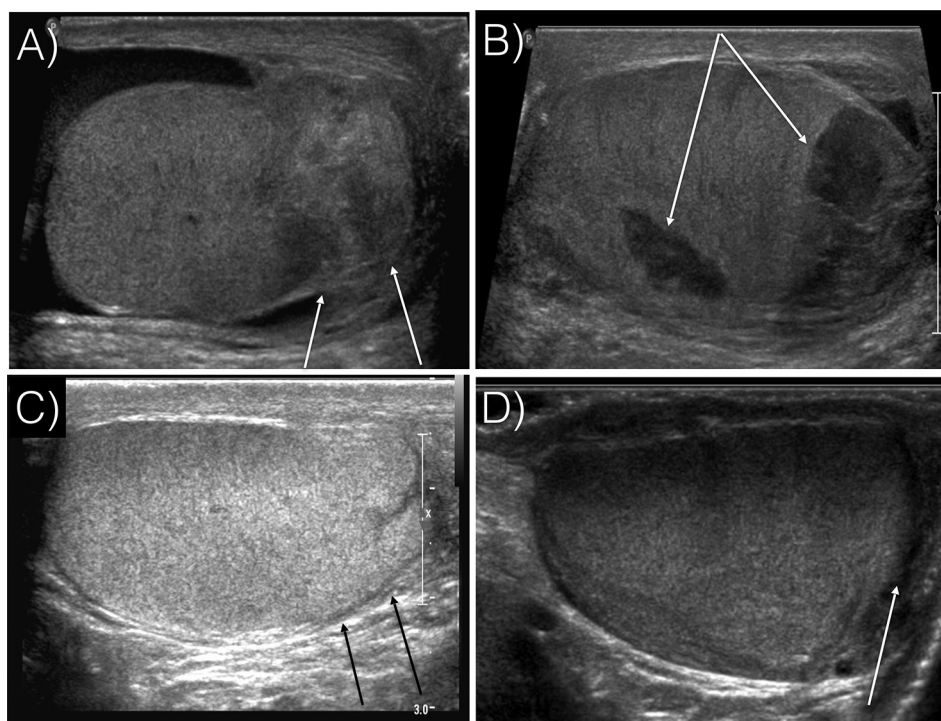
Pre-operative scrotal ultrasounds with arrows depicting: A) disruption of the tunica albuginea and B) intratesticular hematoma. Six-month postoperative ultrasounds reveal: C) restoration of the tunica albuginea and D) resolving intratesticular ultrasound.
